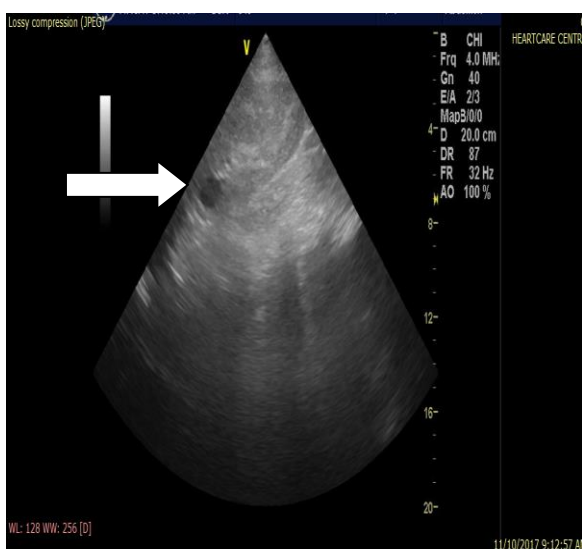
Longitudinal ultrasound scan image showing a simple renal cyst (white arrow) in the superior pole of the right kidney in a 32 year-old female with HIV
